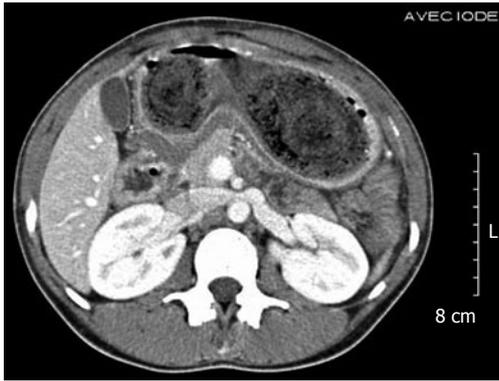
The trichobezoar presented as a heterogenous non-enhancing mass in the stomach on computed tomography scan with IV contrast.
